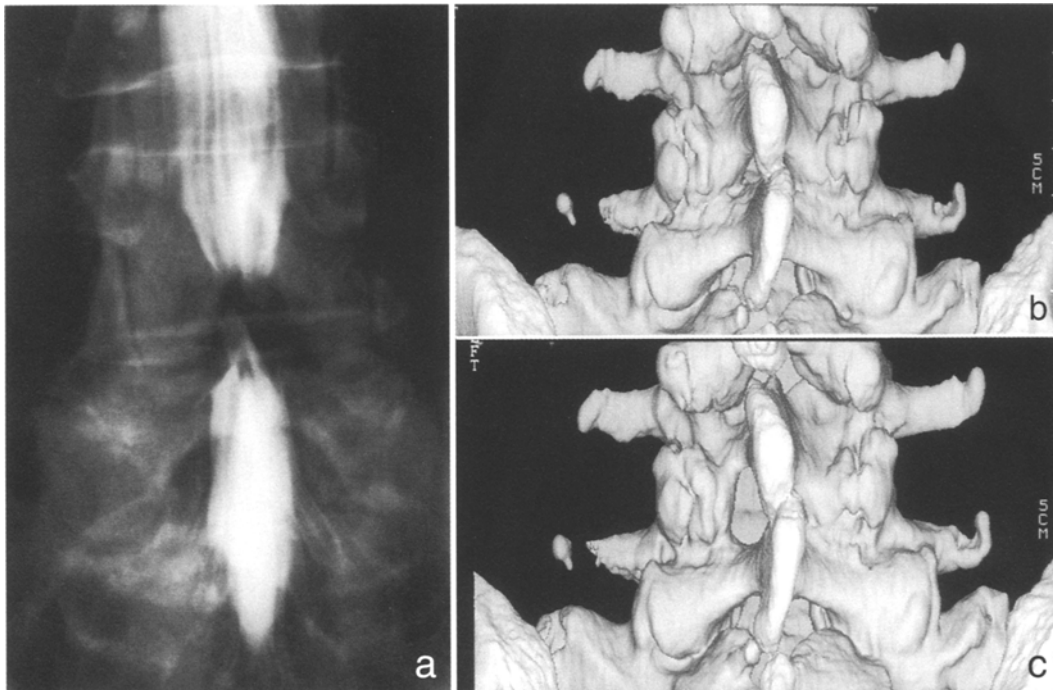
Images of a 56 years old woman with symptomatic spinal stenosis L4-L5. (a) Pre-operative myelogram (antero-posterior view) showing a monosegmental hourglass stenosis with subtotal obstruction of the spinal canal due to bilateral hypertrophy of the facets and the ligamentum flavum. (b) Pre-operative 3-D CT-scan. (c) Postoperative 3-D CT-scan demonstrating the bony resection of the unilateral surgical approach
